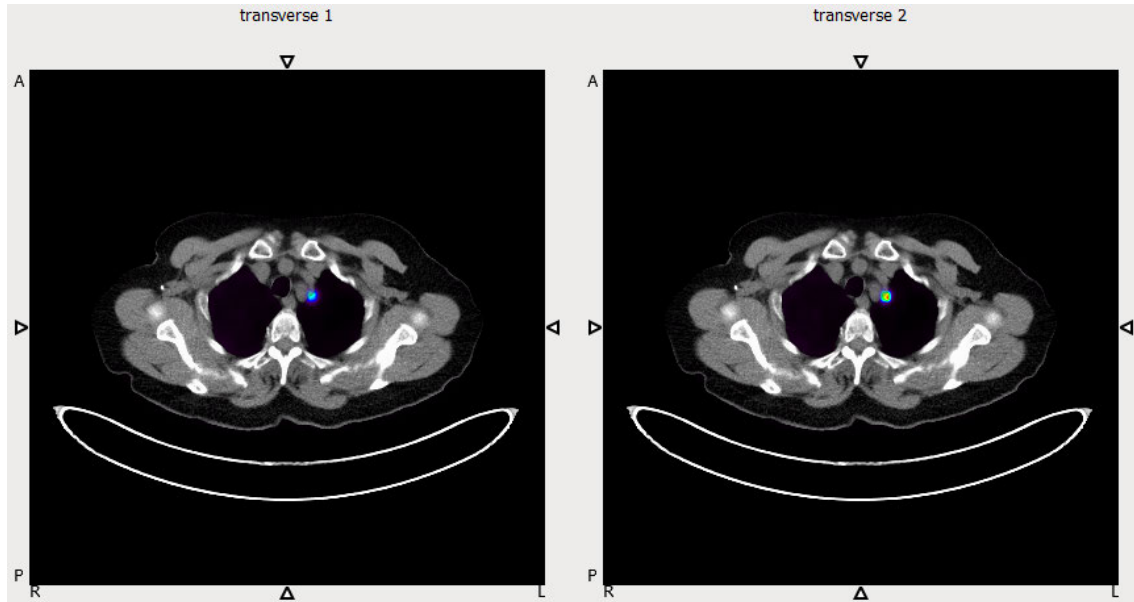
Patient 04: Fused PET<sub>0</sub>/CT image (left) and PRC<sub>5</sub>/CT image (right) where lesion located between soft-tissue and lung.
